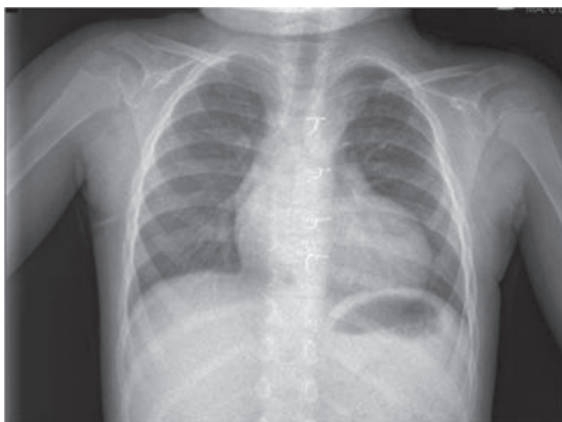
Chest X-ray after extubation and eight days of noninvasive ventilation.
